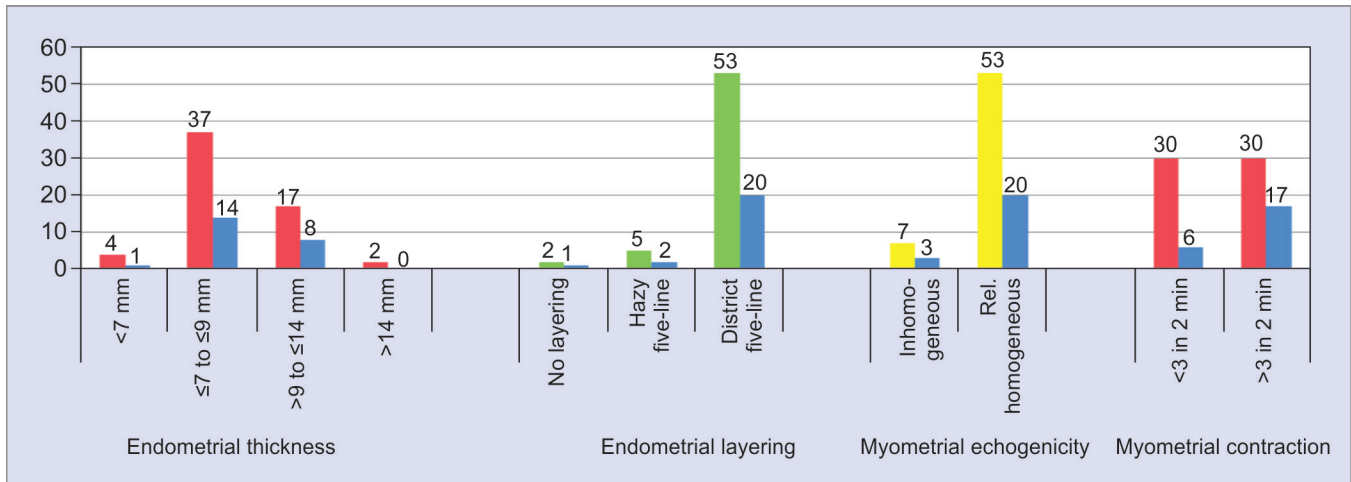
Correlation of ultrasonographic parameters with pregnancy rate
